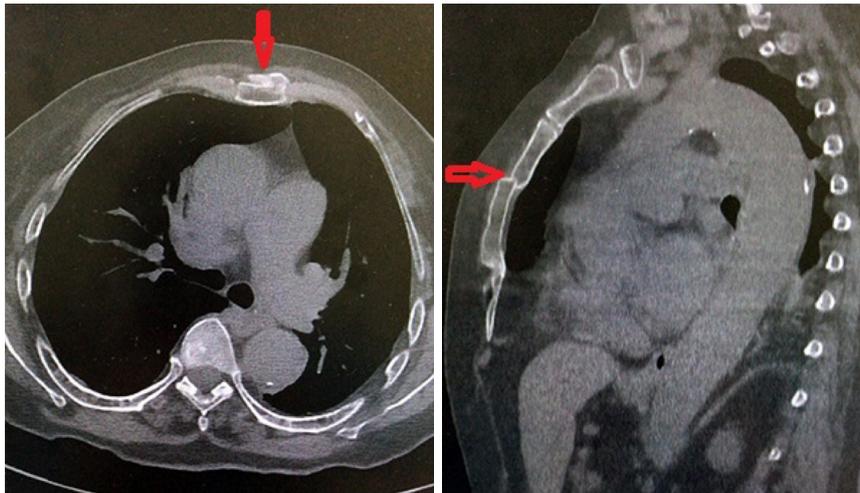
Chest CT scan images of the patient. Fracture line marked with arrows, and can be clearly seen in multiplanar reconstruction view (right).
